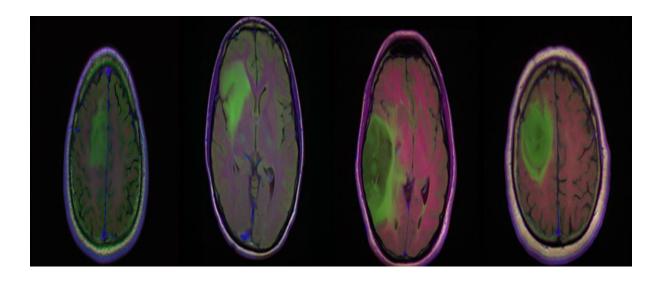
Brain MRI Dataset Input Images
